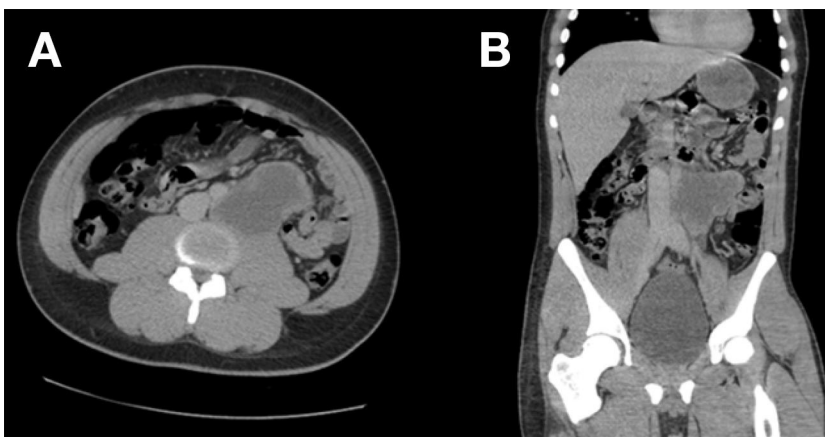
Axial (A) and coronal (B) computed tomograms showing a left sided retroperitoneal metastasis, which was causing backache
